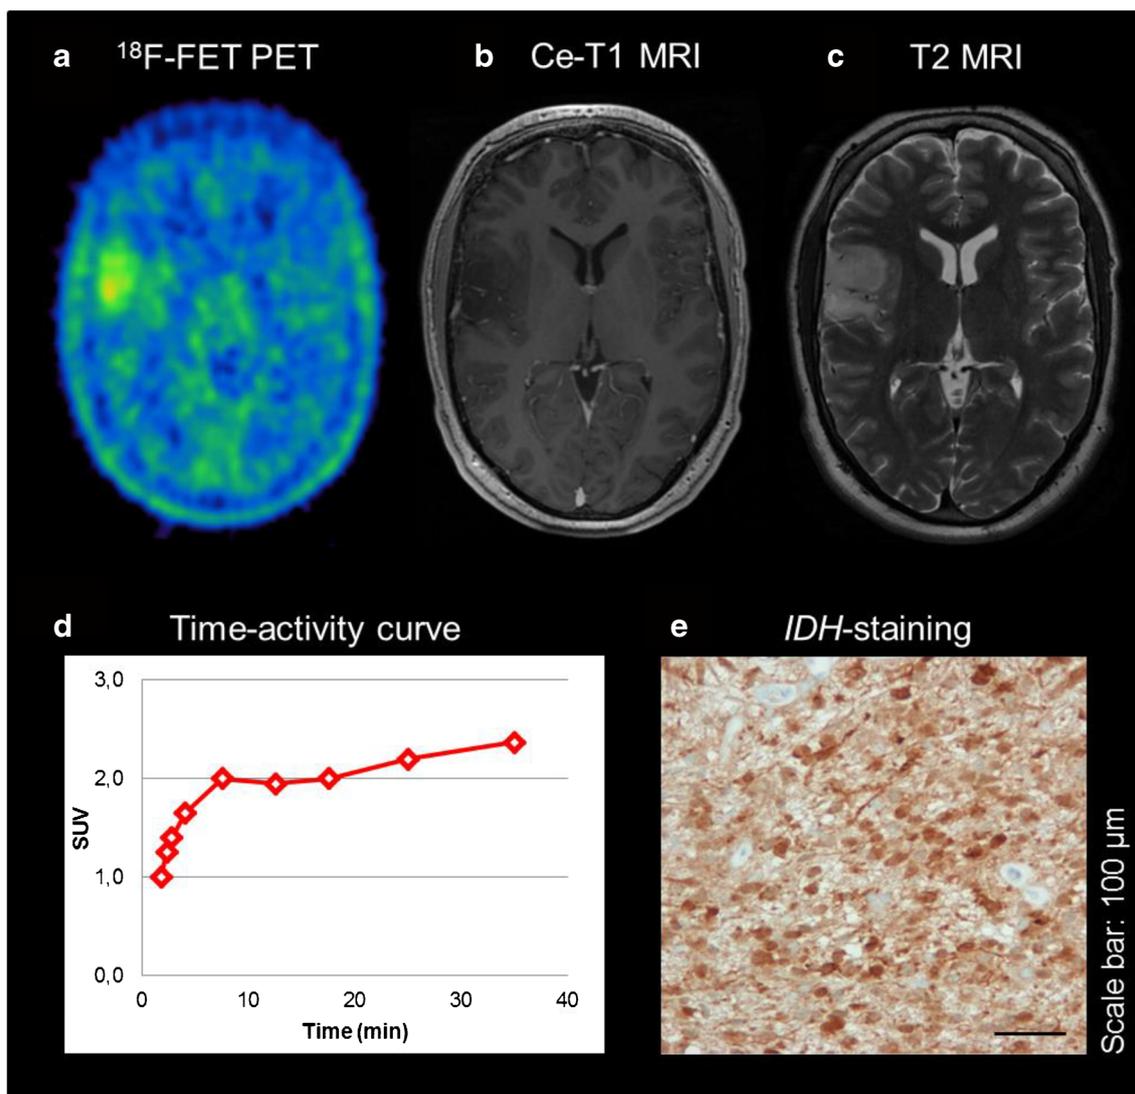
Example of a patient with a ^{18}F -FET-positive lesion in the right temporoparietal lobe, moderate TBR_{max} 2.2 and rather small BTV of 6.8 ml a without contrast-enhancement in CE-T1 MRI b and a small
